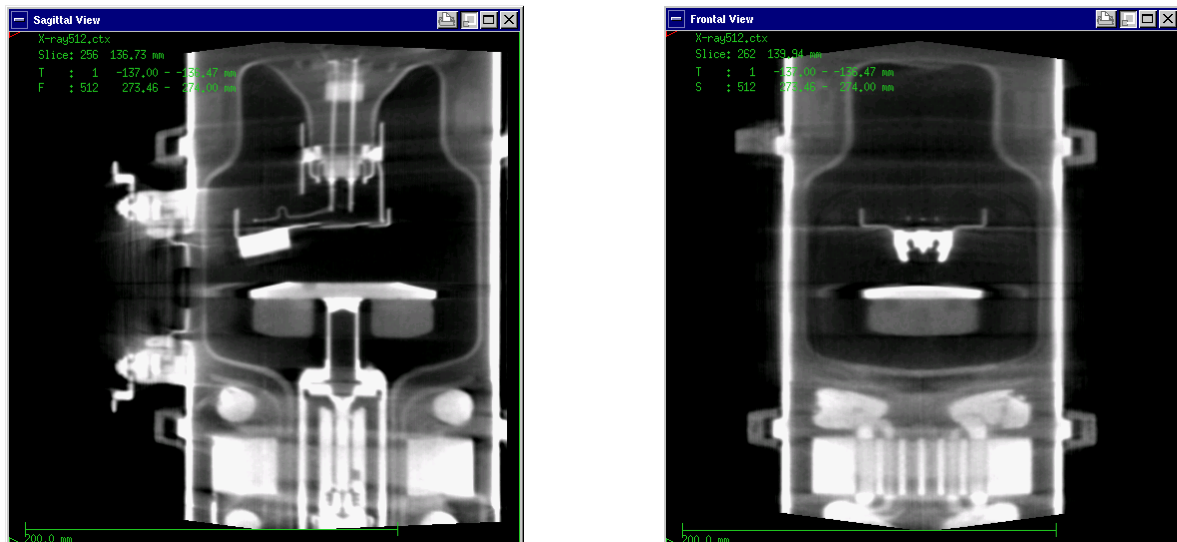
Sagittal and frontal cross sections of an X-ray tube from a MV cone beam CT without collimator. In the sagittal view, the arrangement of the cathode and anode target is visible. In this view, the photon beam exits the tube towards the left. The frontal view offers a more detailed view on the cathode geometry.
